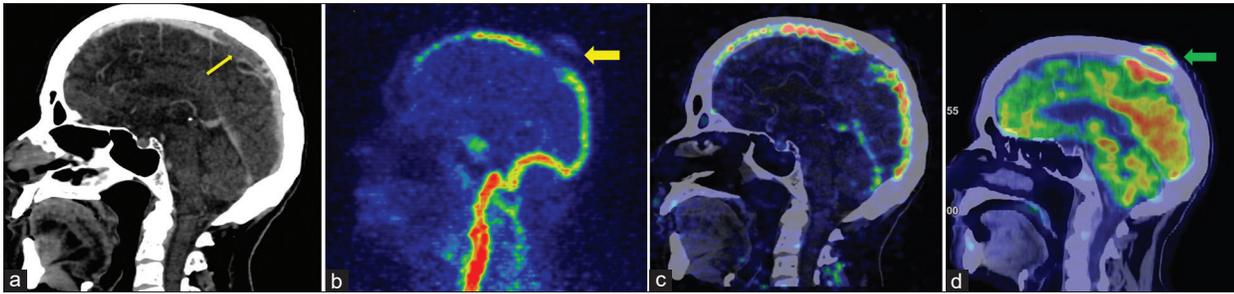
Filling defect in the superior sagittal venous sinus in CT venography image [thin yellow arrow, a], on the the venous phase of early dynamic PET images [lateral projection of theMIPimage,boldyellowarrow,b and fused PET/CT images,c]. FDG avid enhancing lesion in the high parasagittal region of the parietal scalp infiltrating the superior sagittal sinus [green arrow, d]
